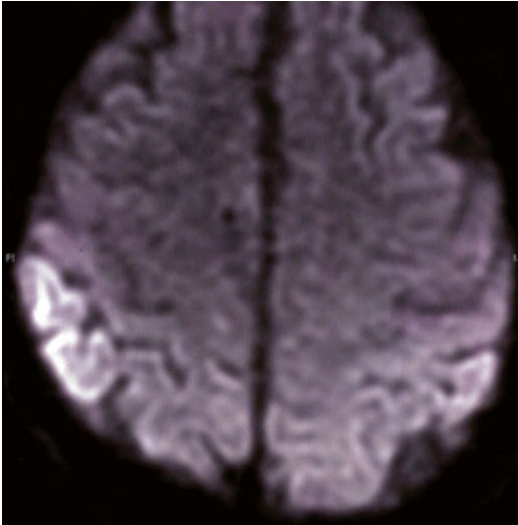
Prion disease case example: A 75-year-old male was eating at a local fast food restaurant and suddenly acted odd and dropped everything from his hands with a blank stare on his face. He was brought emergently to the ER where it was initially thought that he may have had a brainstem stroke, yet MRI was negative for this. He recovered back to baseline within a day or two but then came back again with indeterminate spells of loss of consciousness and confusion, disorientation that progressed rapidly. He had a witnessed generalized seizure and had repeat MRI scans that showed hyper-intense changes in the right posterior parietal cortex. No clear diagnosis was evident at first but Creutzfeldt–Jakob disease was suspected, with CSF and repeat MR diffusion imaging confirming this as Creutzfeldt–Jakob disease (CJD); the illness was ultimately fatal 4 months later with intervening rapid functional decline noted
